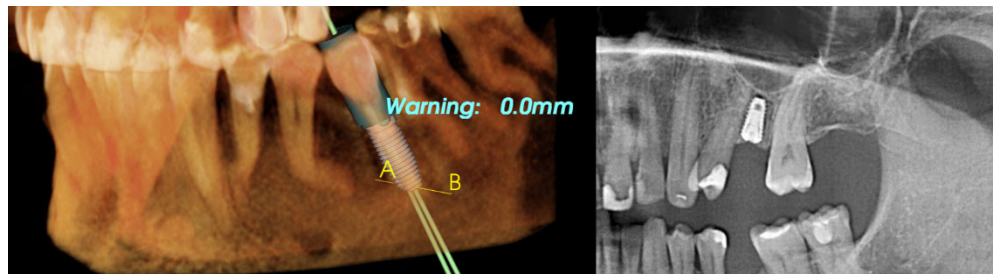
View of the implanted implant in the CBCT image along with the original design bypassing the adjacent tooth with extremely unusual apex anatomy (left) and the view in the OPG image of the implanted implant along the tilted adjacent tooth where insertion of the implant along the distally adjacent tooth would cause its perforation
